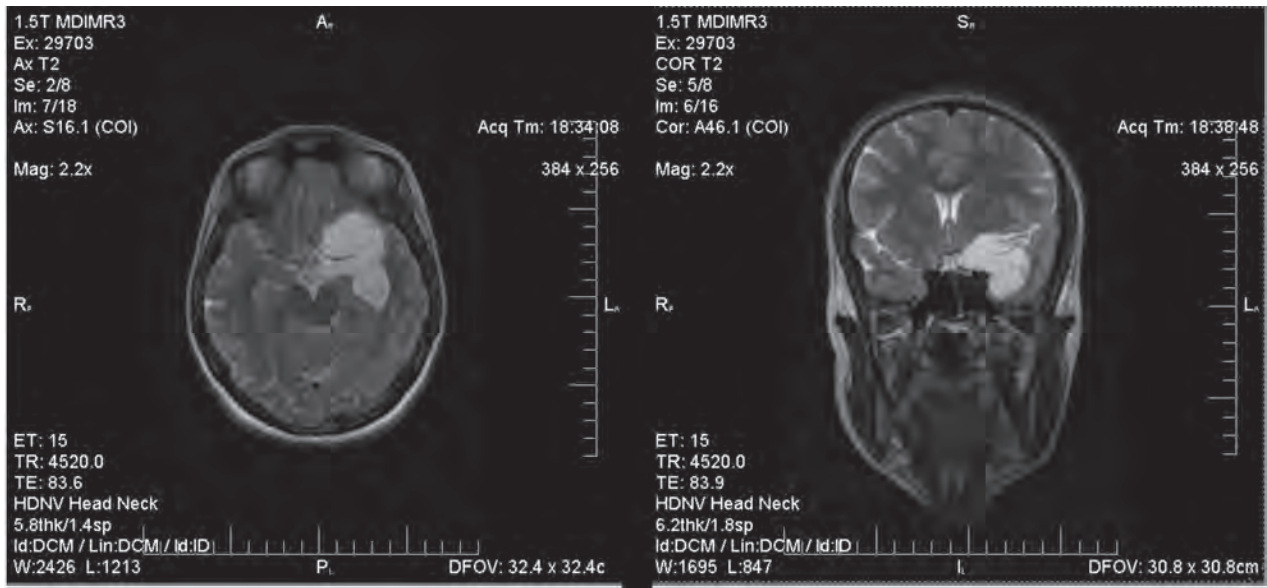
Pre-operative brain MRI (T2-FLAIR). A huge lobulated extra axial enhanced brain lesion, embedded on left Sylvain fissure with extension to Para seller region
